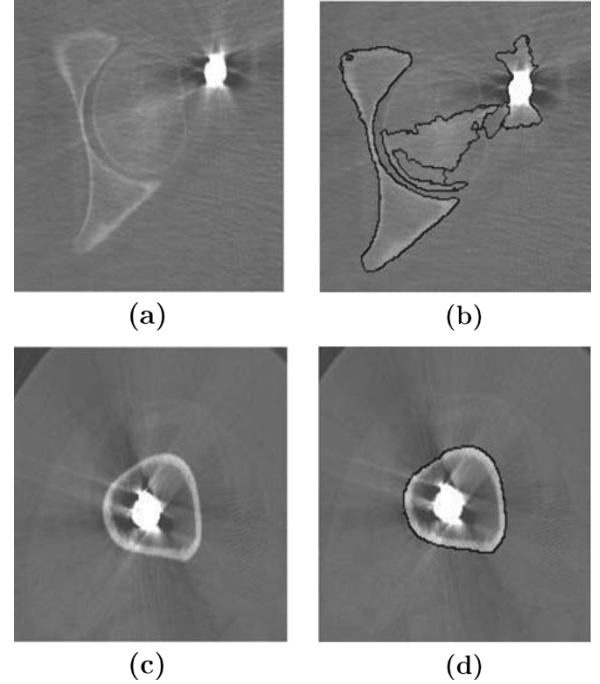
Segmentation of CT slices with iron by our algorithm. (a), (c) The original CT slices of a human leg. (b), (d) The edge maps of slices (a) and (c), respectively.
